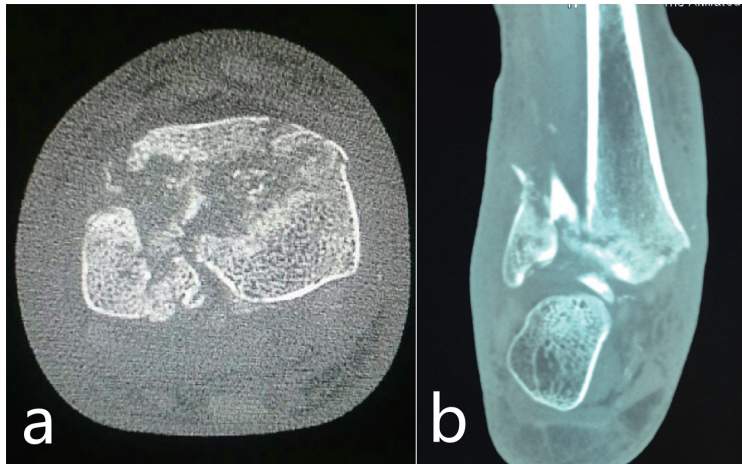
Comminuted intraarticular fracture of the distal tibia with concurrent fibular fracture and valgus malalignment in preoperative CT sections
